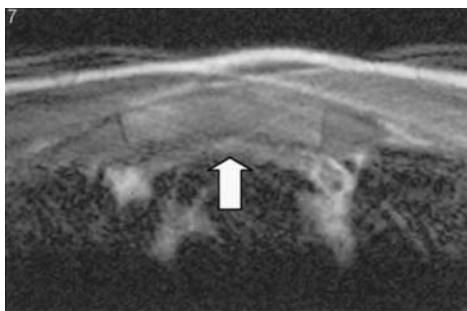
Magnetic resonance (MR) images. Left The signal intensity of the tumor is slightly lower or almost identical (*arrow*) to that of the skeletal muscle on a transverse T1-weighted image. Right Sagittal T2-weighted image shows that signal intensity of the tumor is higher (*arrow*) than that of the skeletal muscle
